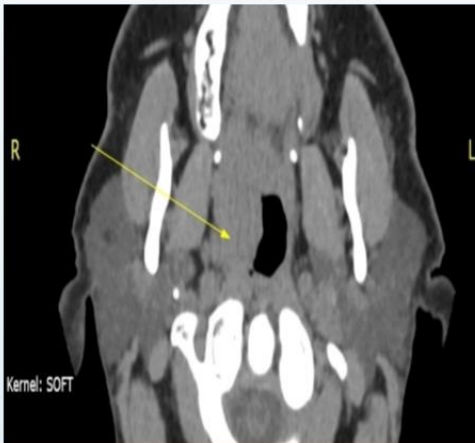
presents a computed tomography (CT) scan of the paranasal sinuses
